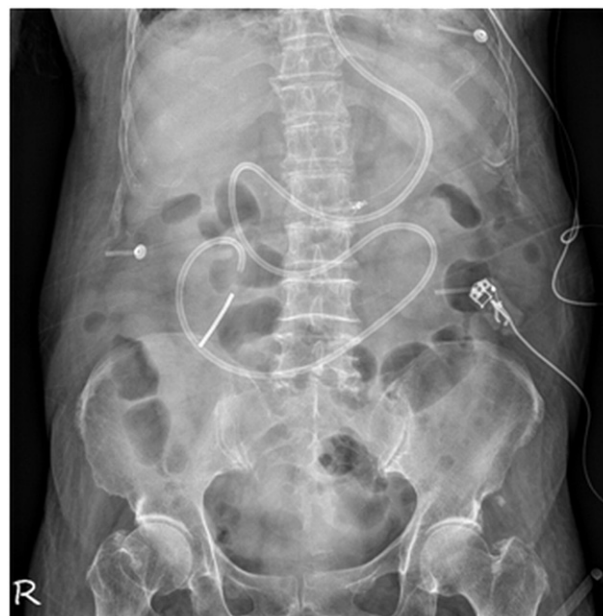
Plain abdominal radiograph showing the enteral feeding.
